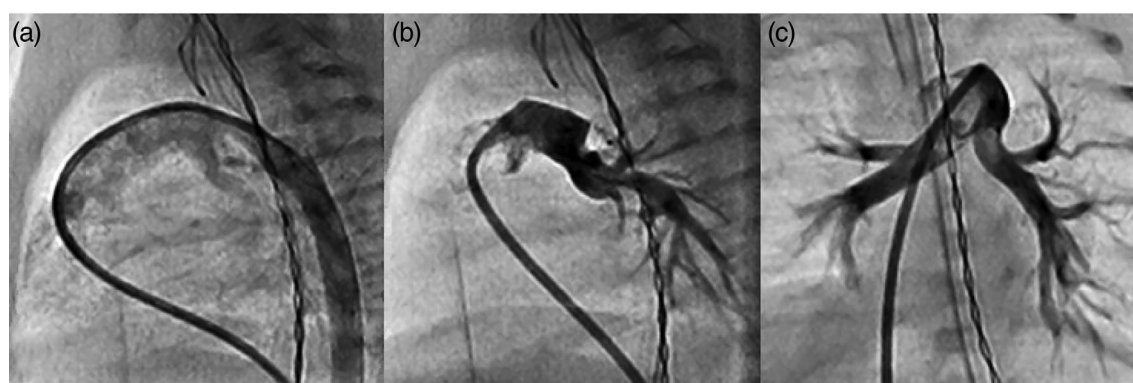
Transcatheter patent ductus arteriosus occlusion with the Micro Plug Set: X-Ray angiography. Intra-procedural X-Ray angiography: Initial lateral plane angiogram with 4 French glide catheter within the ductus to delineate ductal anatomy (a). Repeat angiogram in straight lateral projection (b) and extreme caudal projection (c) through glide catheter, positioned in the main pulmonary artery following device deployment demonstrating unobstructed flow to the branch pulmonary arteries and occluded ductus with device in stable position
